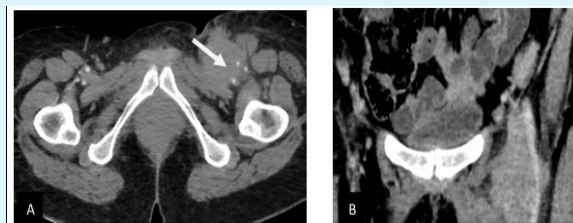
Preoperative contrast-enhanced CT image showing a bulky left inguinal nodal mass with vascular involvement.
